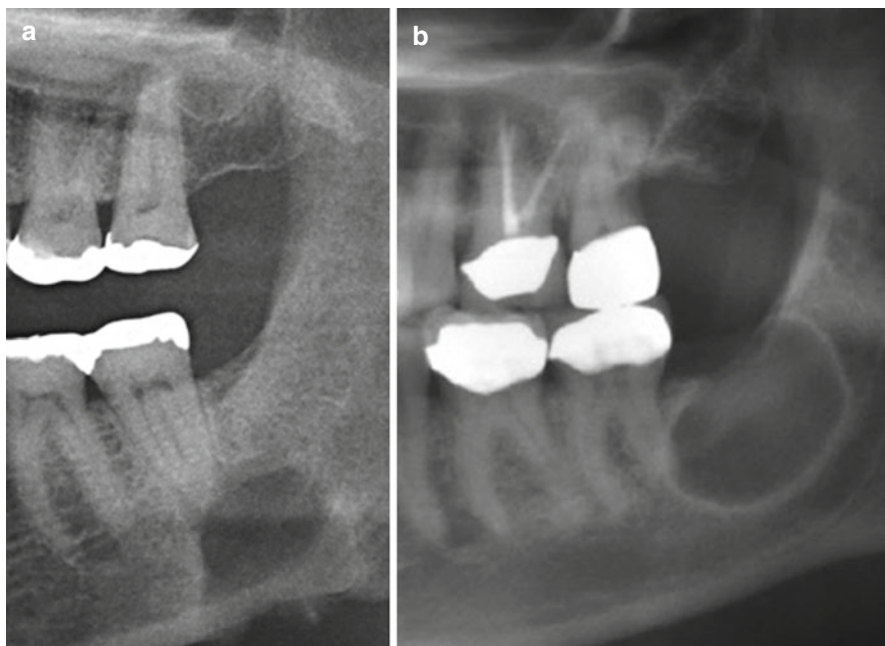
(a) Periapical cyst with well-defined radiolucency at the apex of tooth #18. (b) Well-defined radiolucency with a sclerotic border distal to the roots of tooth #18
